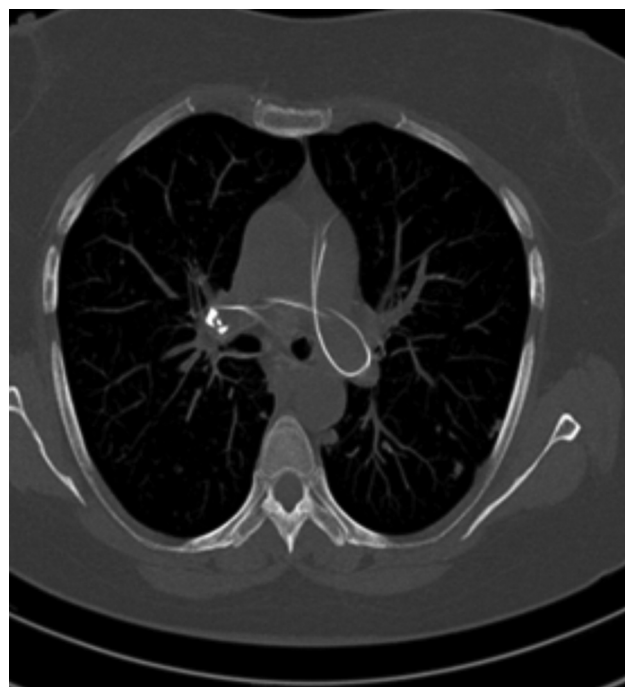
HRCT axial cuts demonstrating presence of the coiled PICC line in the left pulmonary artery (yellow arrow). HRCT, high-resolution computed tomography; PICC, peripherally inserted central catheter.
